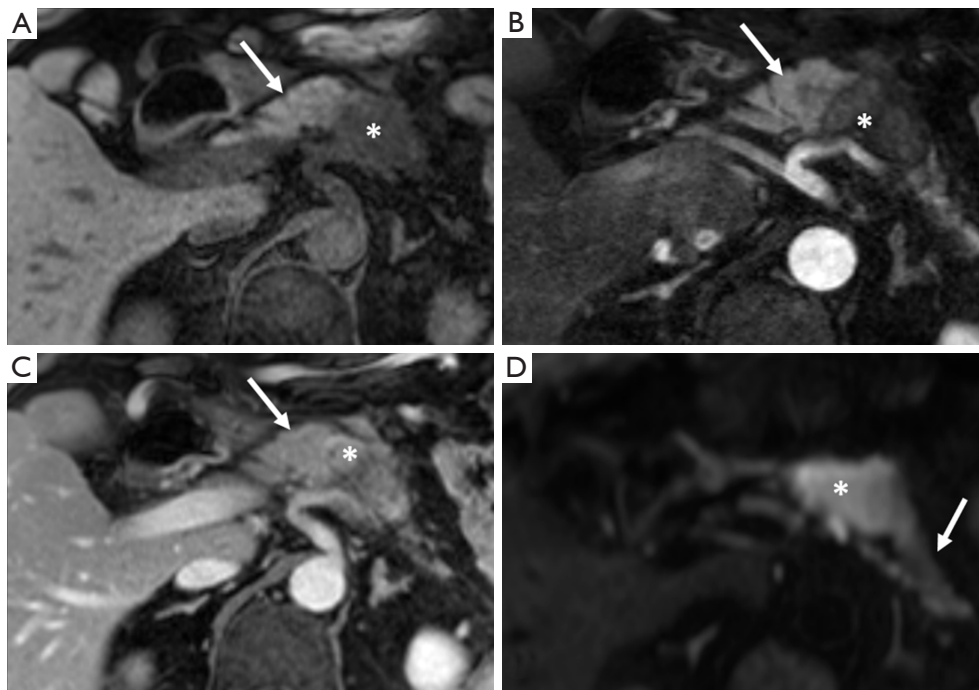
MRI of pancreas body mass. Axial (A) noncontrast, (B) arterial, (C) portal venous, and (D) DWI MR images in a 73-year-old man with new onset diabetes mellitus demonstrate a 4 cm pancreatic body mass (asterisks) that is T1 hypointense (A), hypoenhancing (B-C), and diffusion restricting (D) compared to the adjacent normal parenchyma (arrows). MRI, magnetic resonance imaging; DWI, diffusion weighted imaging.
